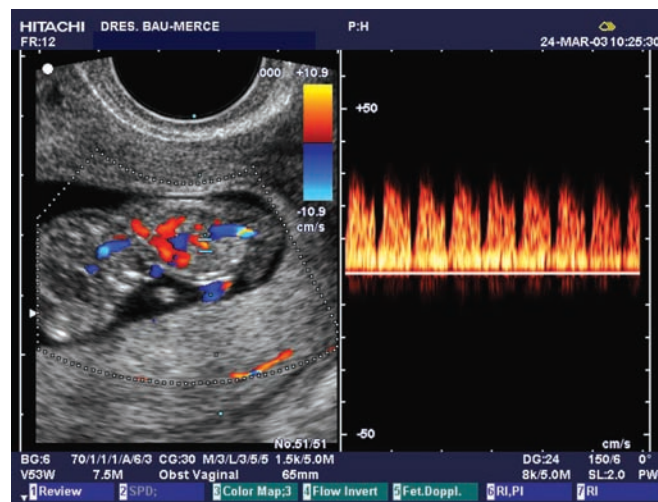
Normal Doppler recording of the ductus venosus in the 11th week.
